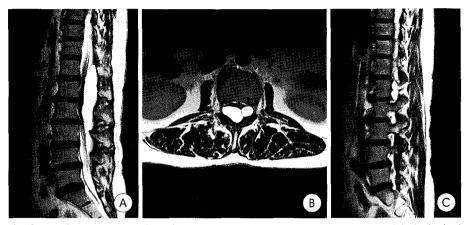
A, B: Sagittal and axial T2— weighted magnetic resonance images reveal two septated extradural cysts separated by septations posterior to the spinal cord, which is compressed severely forward. C: Sagittal T2—weighted magnetic resonance image shows that the cyst protrudes through intervertebral foramen.
